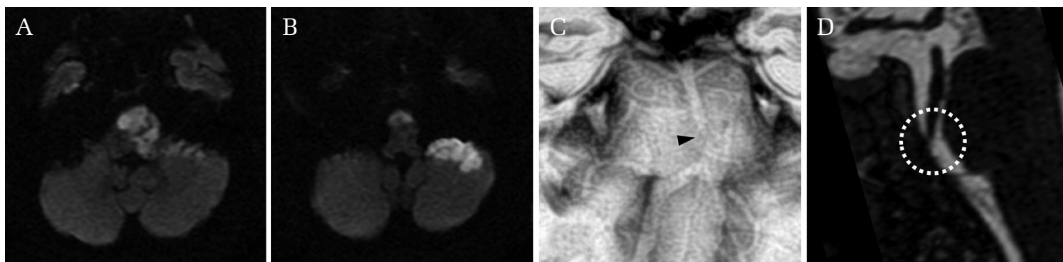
Magnetic resonance imaging (MRI) of the head on day 5 (A, B) showed hyperintensities in the area of the pontine arteries and the left anterior inferior cerebellar artery. Basi-parallel anatomic scanning MRI (BPAS-MRI) on day 6 (C) revealed that the outer contour of the basilar artery was narrowed at the middle portion of the clivus (*black arrow*). BPAS-MRI on day 18 (D) showed that the basilar artery trunk was tethered to the clivus (*white dotted circle*).
